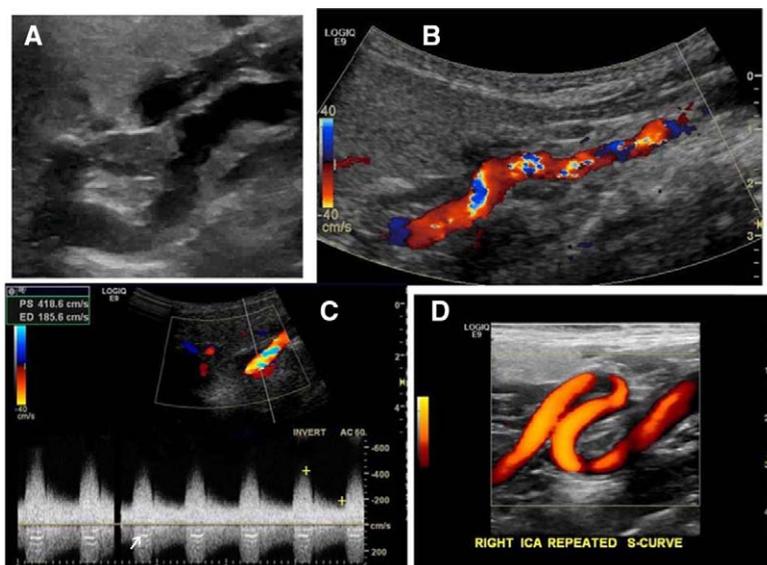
Typical duplex ultrasound findings of carotid fibromuscular dysplasia. A, B-mode imaging showing the beading and tortuosity of the mid and distal internal carotid artery. B, Color Doppler of the distal internal carotid artery exhibiting the typical pattern of tortuosity and marked turbulence. C, Color Doppler showing turbulence and spectral analysis demonstrating high peak systolic (419 cm/s) and end-diastolic velocities (186 cm/s). The “seagull” sign (arrow) indicates that the stenosis is quite severe. D, Color power angiography demonstrating severe tortuosity and redundancy (S curve) of the internal carotid artery.
